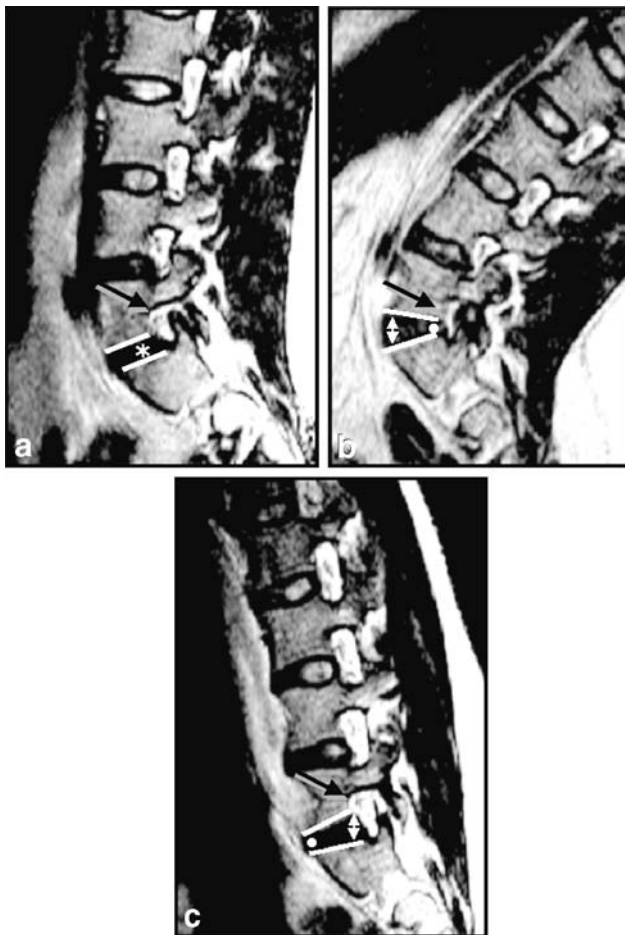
Unoperated *positional intervertebral disc herniation*. a Recumbent midline sagittal T2-weighted fast spin echo MRI (rMRI) showing degenerative disc disease at the L5–S1 level associated with a minor posterior disc bulge/protrusion (arrow). b Upright-neutral midline sagittal T2-weighted fast spin echo MRI (pMRI) revealing gravity-related narrowing of the intervertebral disc space (asterisk) and a posterior disc herniation (arrow) not seen on the recumbent image. There may be a minor component of increased retrolisthesis relative to the recumbent study at this level as well.
